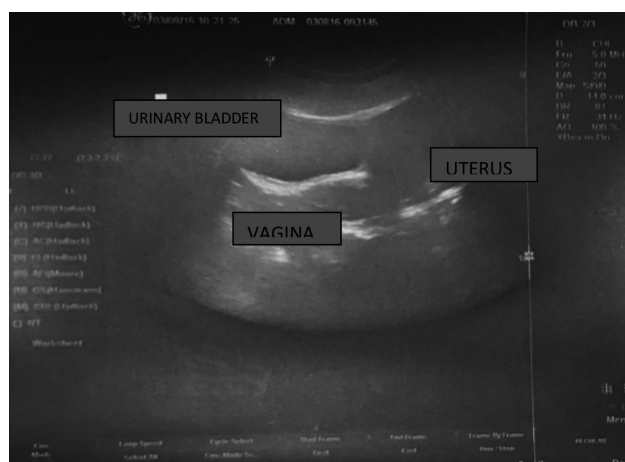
The ultrasonographic appearance.
